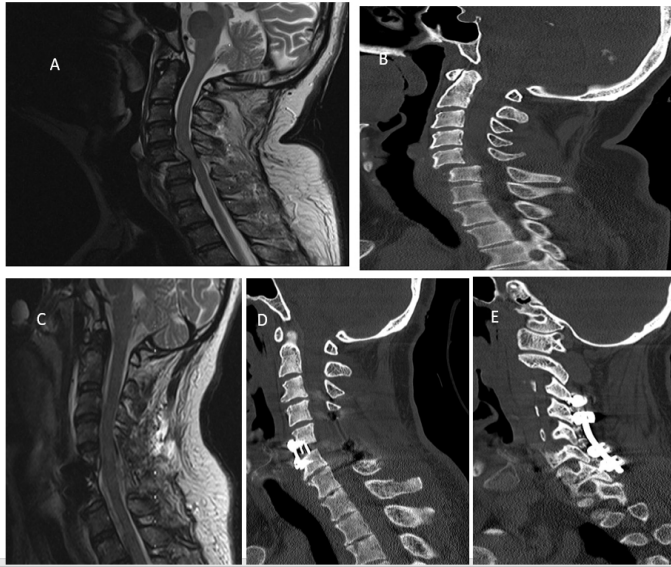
Radiological imaging of a patient operated both anteriorly and posteriorly. A) Preoperative T2-weighted sagittal MRI showing anterolisthesis at C5-6 level. B) Preoperative CT showing anterolisthesis at C5-6. C) Postoperative midsagittal T2-weighted MRI section shows proper decompression of apinal cord. Hyperintensity at the level indicates spinal cord injury at C5-6 levels. D) Postoperative CT shows proper alignment of cervical spine and anterior fusion material at the operated level. E) Post-operative CT shows proper alignment of cervical spine and posterior fusion material at the operated level
